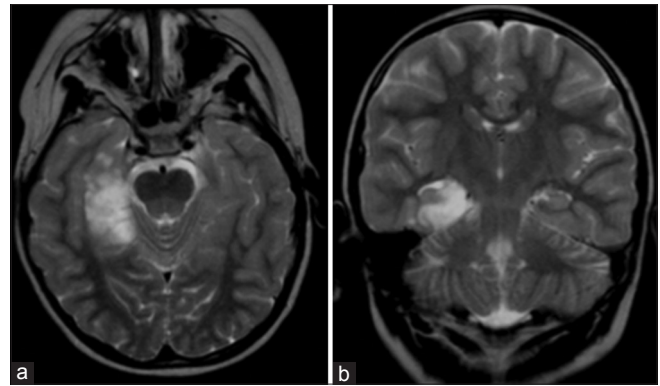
(a and b) Preoperative axial and coronal T2 weighted MR images demonstrate the well-delineated hyperintense mass in the right medial temporal lobe and hippocampus (1994)
